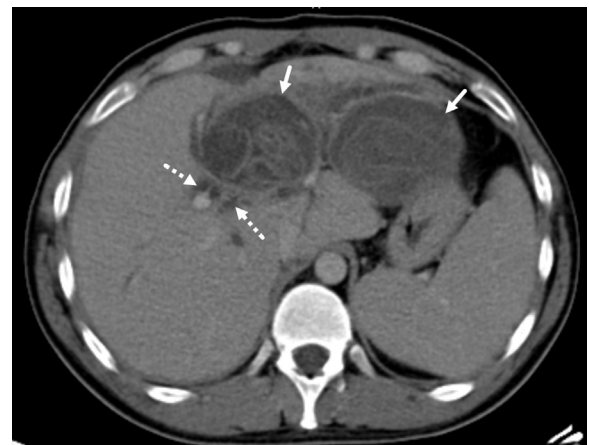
Axial contrast enhanced computed tomography scan of the abdomen with soft-tissue window settings (window width of 350 Hounsfield units (HU) and window level of 50 HU) shows unilocular hepatic cysts with detached laminated membranes compatible with hepatic hydatid cysts on segment II and IV (white arrows). Intrahepatic biliary duct dilation also seen (white dashed arrows).
